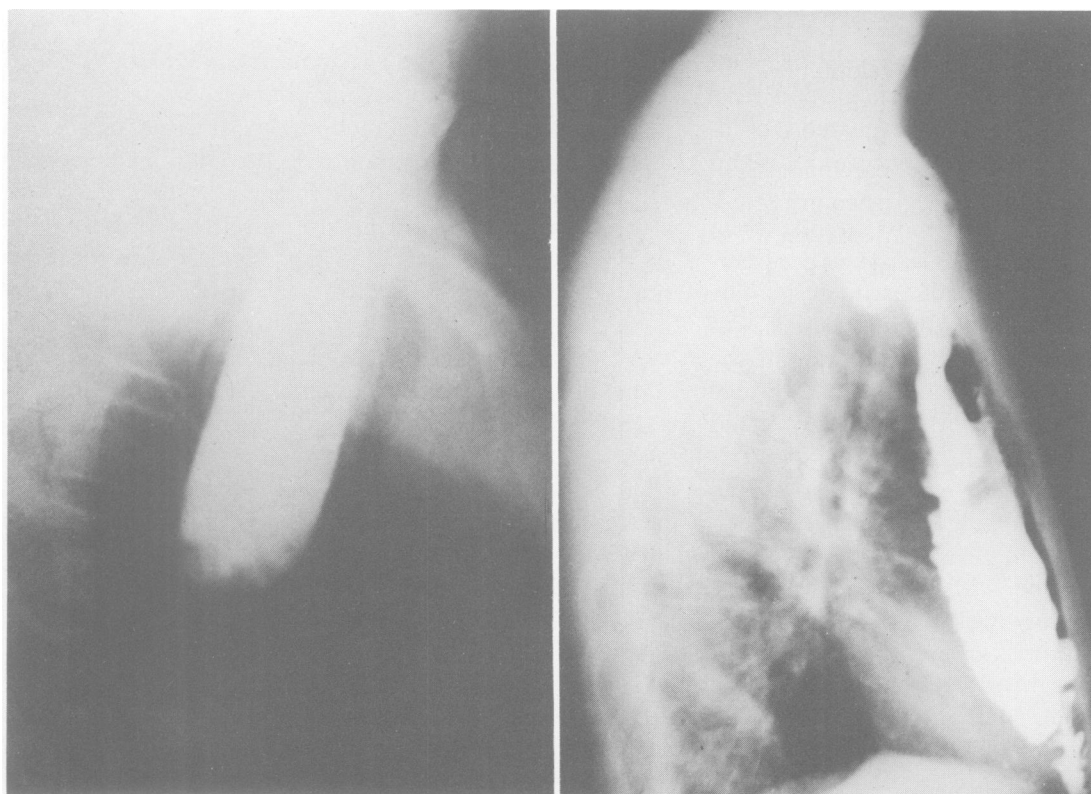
(left) Esophagogram of a 16-year-old boy with lye injury in the middle third of the esophagus. FIG. 2b. (right) Roentgenogram of the same patient 5 years after esophagoileocoloplasty showing extensive filling of the transplant.
